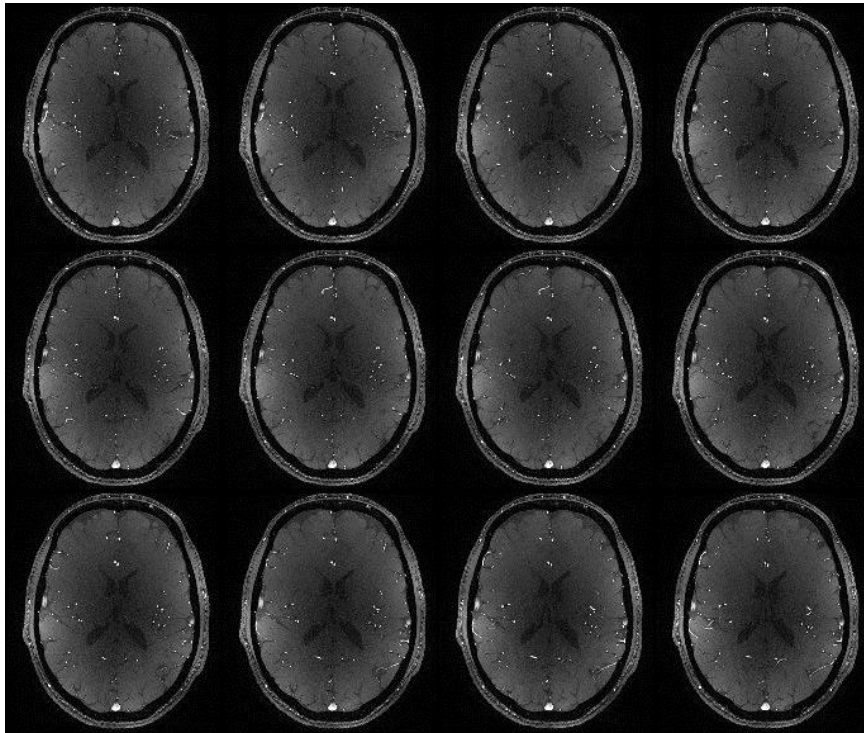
Example of 3D MRI montage of a normal brain
